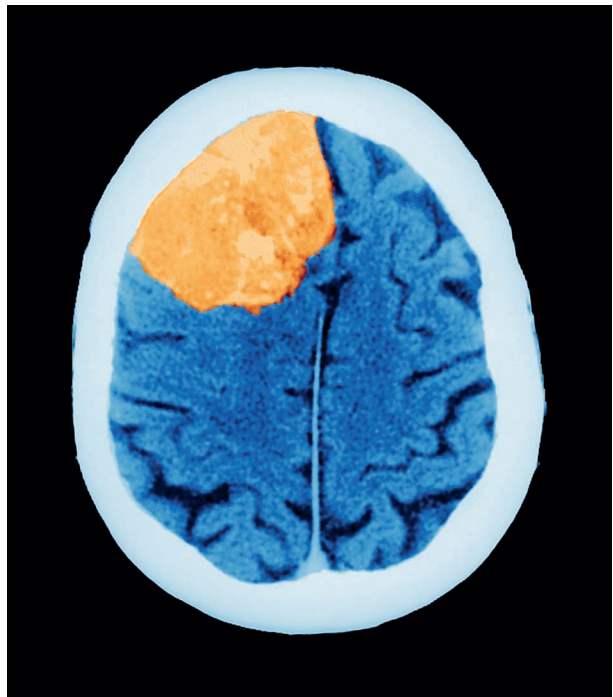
A tumor (here shown on a CT scan) can make it hard to estimate lesion size, and the distortion in the shape of the brain makes it hard to map onto a standard atlas.
